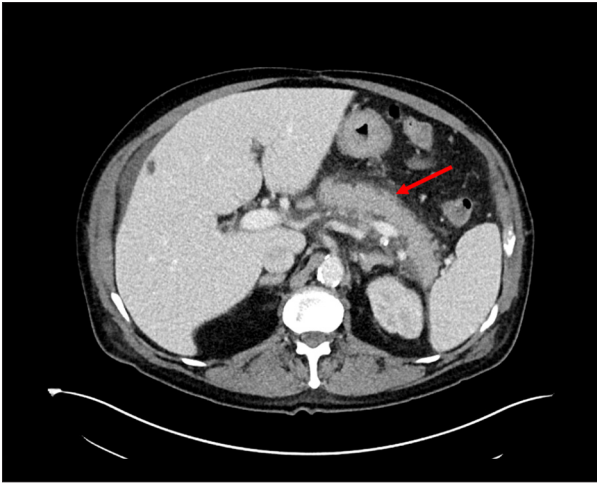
CT scan of abdomen and pelvis showing acute interstitial edematous pancreatitis (red arrow) without evidence of necrosis or fluid collection.
